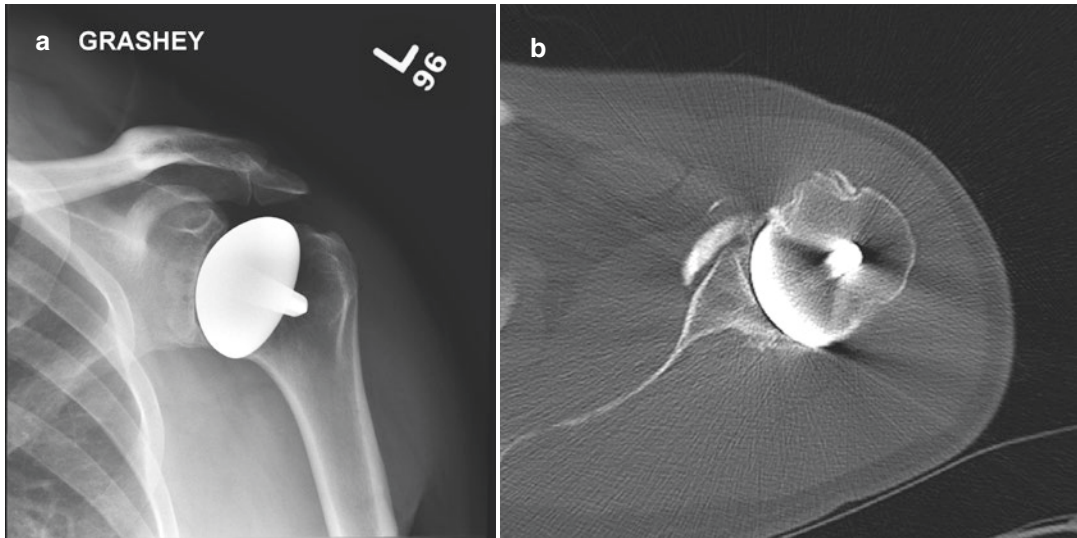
Glenohumeral arthritis post-resurfacing. (a) Grashey radiographs and (b) axial CT arthrogram images show severe glenohumeral joint-space narrowing, particularly posteriorly, with subchondral sclerosis in a patient with left humeral head resurfacing
